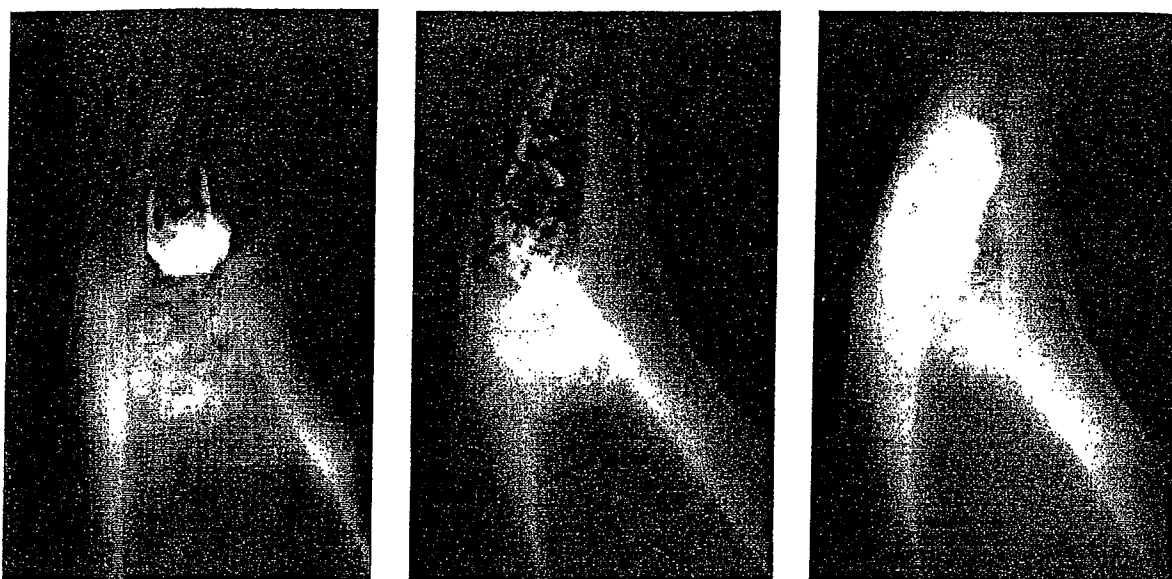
Contact radiographs after 2 months, showing mineralization of induced dentin much more diffuse and porous with carrier alone (a, left) compared with BMP-2 with carrier (b, center) and BMP-4 with carrier (c, right). Bars represent 2 mm.
